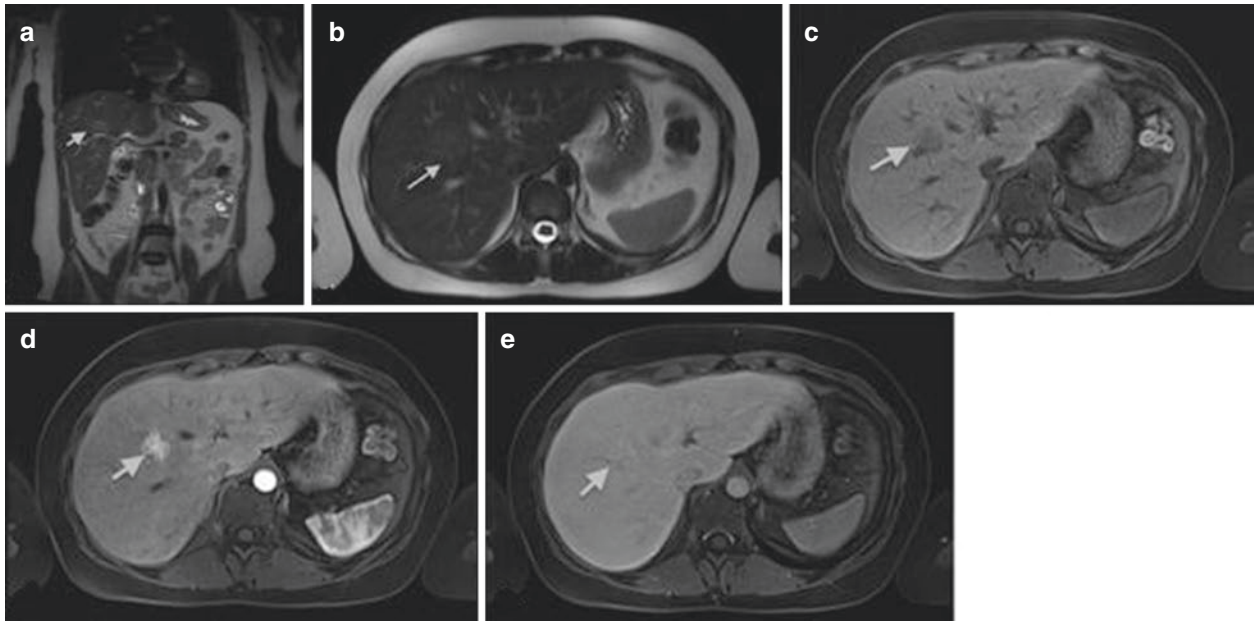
MRI showing focal nodular hyperplasia (FNH) in a 16-year-old girl. This lesion is discretely hyperintense on T2-weighted images (a, b), hypointense on T1-weighted images (c), with intense early arterial phase enhancement (d) and isointense aspect compared to normal
